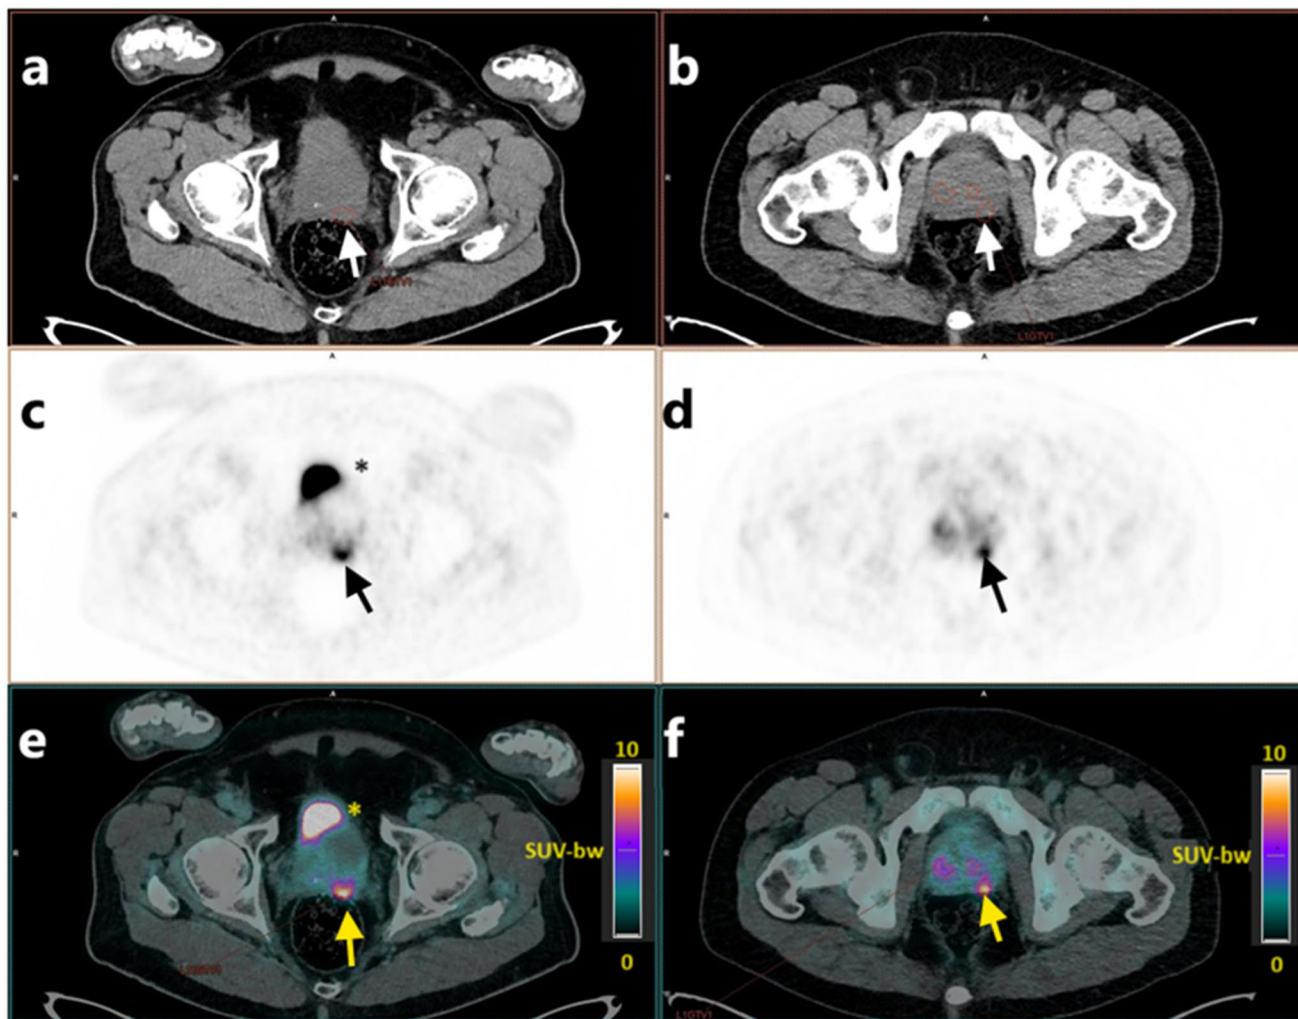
Two pictorial cases of $[^{68}\text{Ga}]\text{Ga-PSMA-11}$ and $[^{18}\text{F}]\text{F-PSMA-1007}$ PET/CT in PCa patients for primary staging. VOIs of PET images were propagated on corresponding CT images (a, b) to create RT structures (arrows), as basis for radiomics features' extraction. VOIs had been previously placed to contour primary PCa lesions
